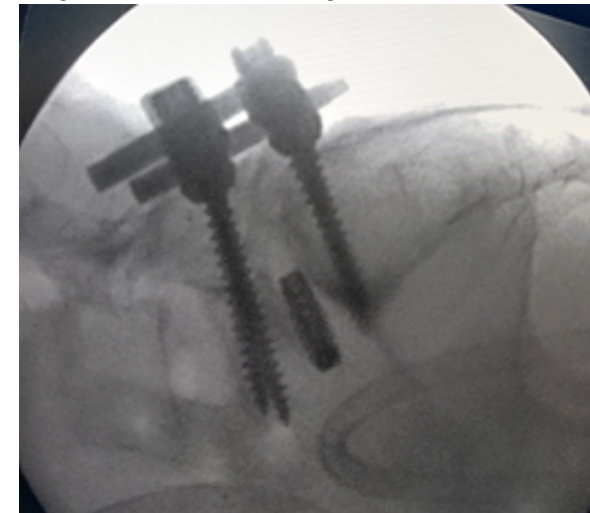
Xray LS spine image of the patient in Image 1 taken intraoperatively showed mild reduction of the listhesis to grade 1. Further reduction was not attempted as we got adequate canal decompression. The patient showed significant improvement in her symptoms postoperatively.
